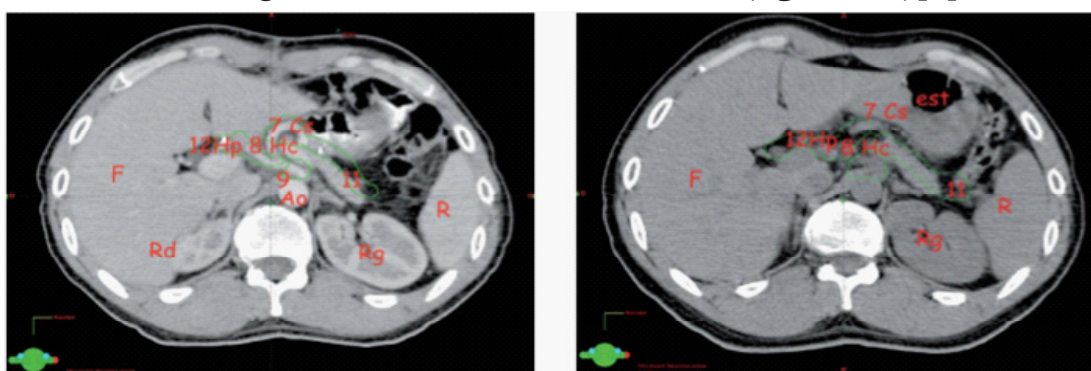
CT delimitation of the subdiaphragmatic lymph node territories involved in stomach cancers on preoperative and postoperative CT. 7: left gastric artery (Cs), 8: common hepatic artery (Hc); 9: celiac trunk; 11: splenic artery lymph nodes; 12: hepatic artery (Hp). AO: descending aorta; Rd: right kidney; Rg: left kidney; F: liver [8].
